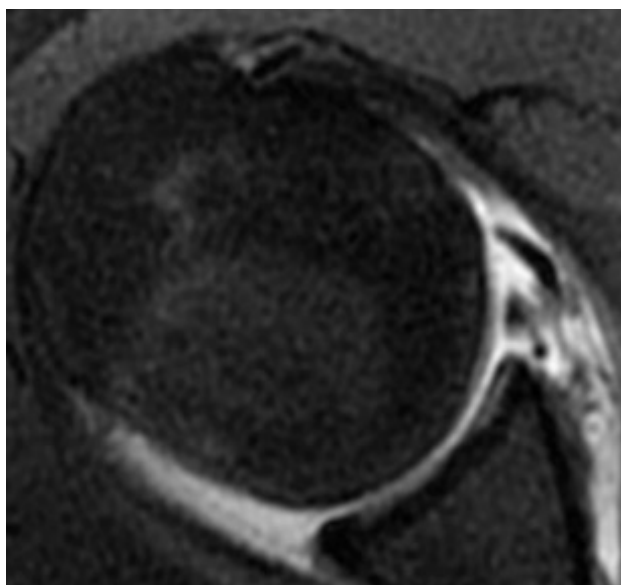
A 22-year-old man with Bankart lesion. Axial T1-weighted fat-suppressed MRA image shows a large interruption of the continued hypointense linear profile of the anteroinferior glenoid labrum.
